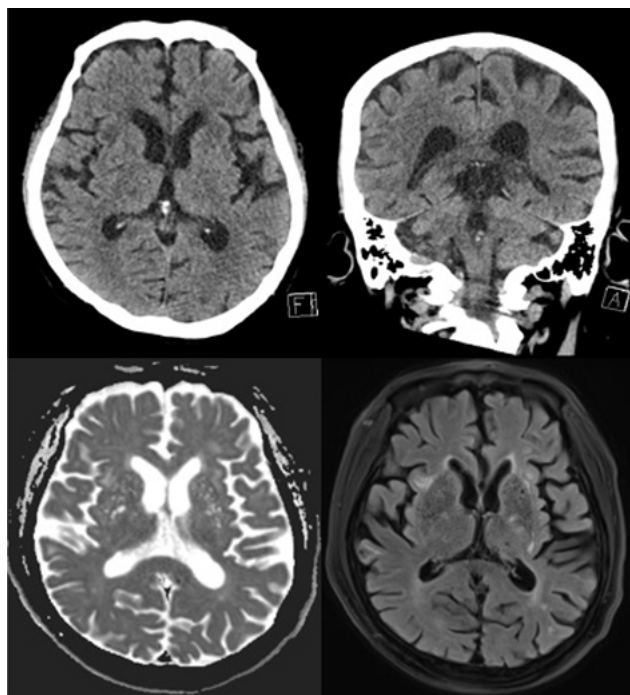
non enhance brain CT and MRI diffusion; no specific abnormalities were observed except for several small old infarctions, as well as mild chronic small vessel ischemia at both periventricular deep white matter.
